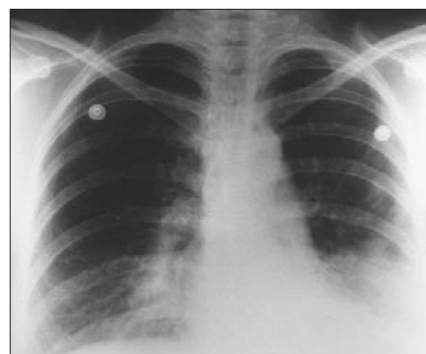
Postero-anterior chest radiograph demonstrating left lower lobe consolidation
